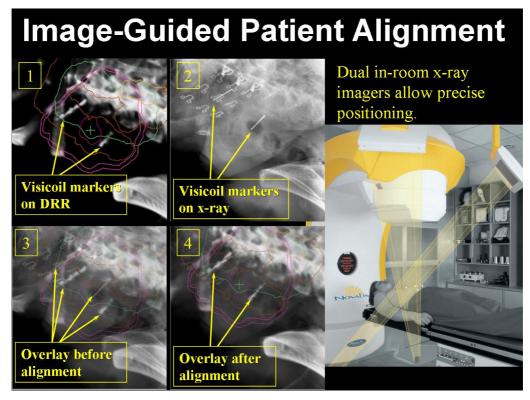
The Brainlab Novalis stereotactic linear accelerator includes two orthogonal diagnostic x-ray tubes and flat panel imagers to provide image-guided 3D patient alignment. Also note visicoil markers used for image-guidance in IGRT/SBRT.
